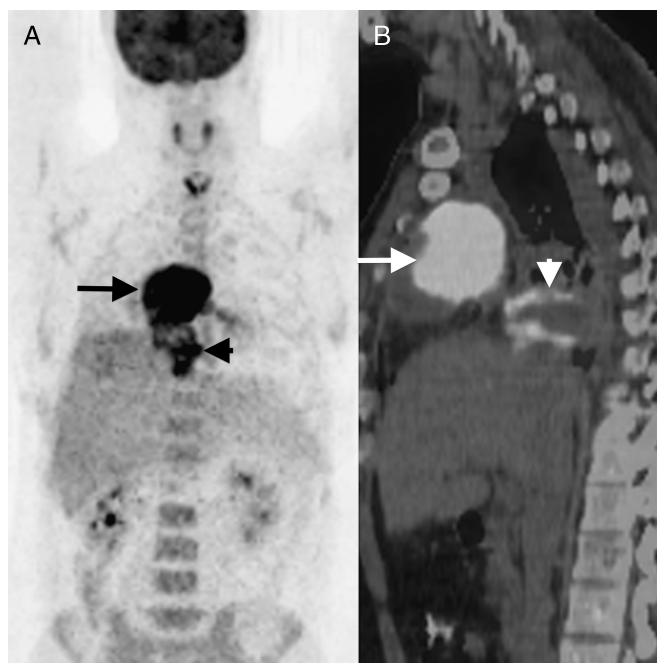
Maximum intensity projection PET (A) and sagittal PET/CT fusion (B) images showed recurrent hypermetabolic masses (arrows). Primary cardiac tumors are rare tumors, and approximately 25% of them were malignant. They consist of sarcoma (95%) and lymphoma (5%).¹ The most common primary cardiac sarcomas, which have poor prognosis, are angiosarcoma and rhabdomyosarcoma. Myxofibrosarcomas, which originated from myofibroblast, are nonvascular tumors and considered as myxoid variant of malignant fibrous histiocytoma.² In literature, there are a few case reports about FDG PET imaging of primary cardiac tumors. Mild FDG uptake was reported in benign primary cardiac tumors. Primary and secondary cardiac tumors showed increased FDG uptake.³⁻¹³ In addition, pericardial tumors and pericarditis had increased FDG uptake.¹⁴⁻¹⁶
